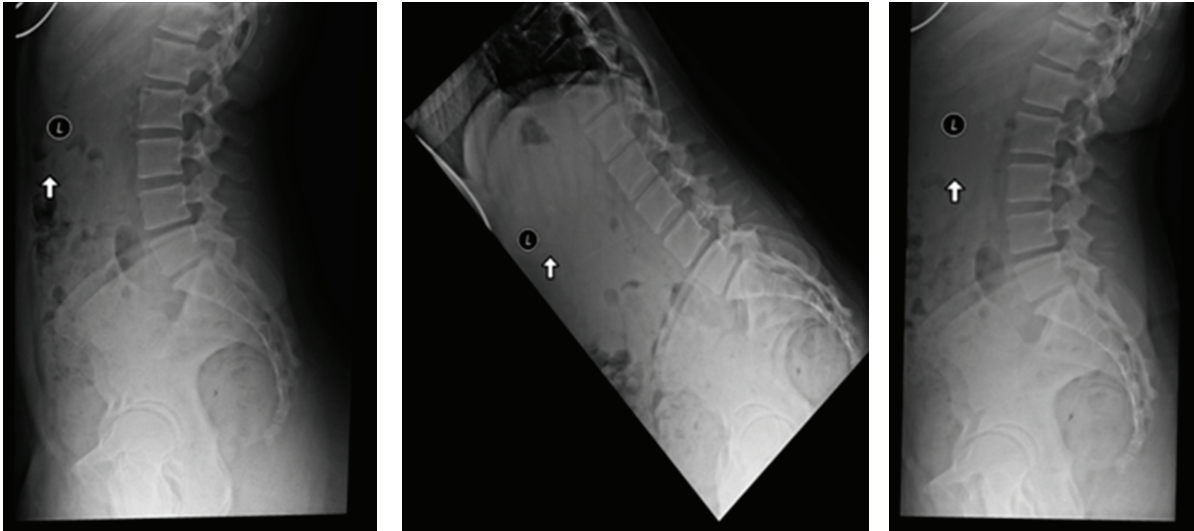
Lateral standing, flexion and extension X-rays are important to identify motion and/or instability in the spine. Some patients have unremarkable lateral upright X-rays but demonstrate a mobile spondylolisthesis upon dynamic testing.
